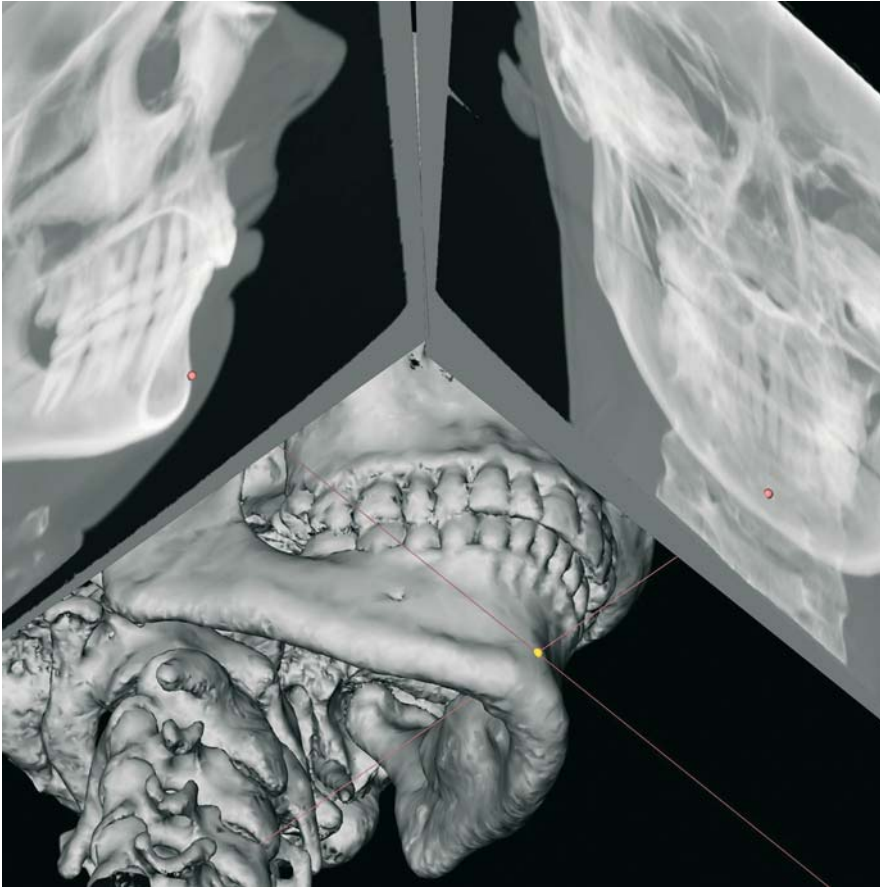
Pogonion. Virtual lateral and frontal cephalograms linked to the 3-D hard tissue surface representation (3-D CT, patient K.C.)
